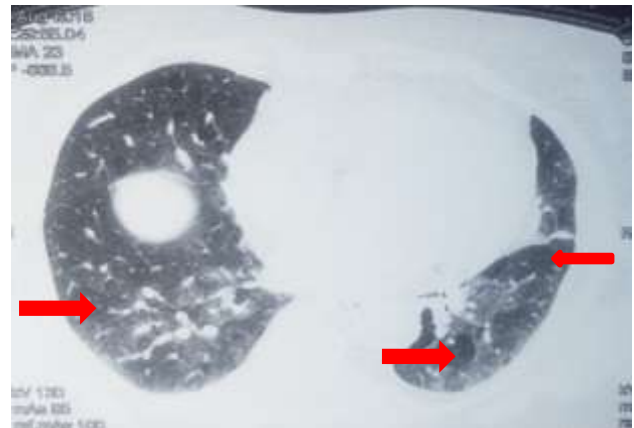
HRCT chest image showing areas of air trapping (noted with red arrows) with mosaic pattern.
